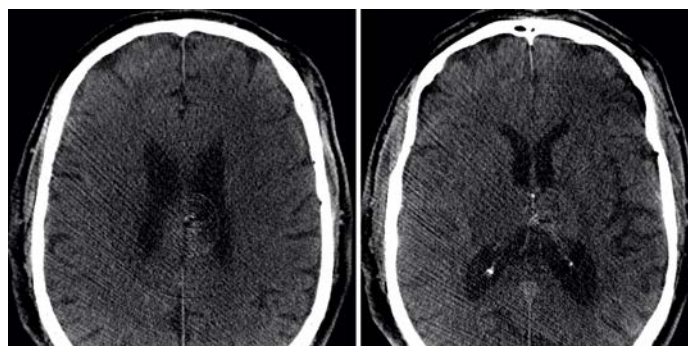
Sine Spin head CT in the angio suite.
